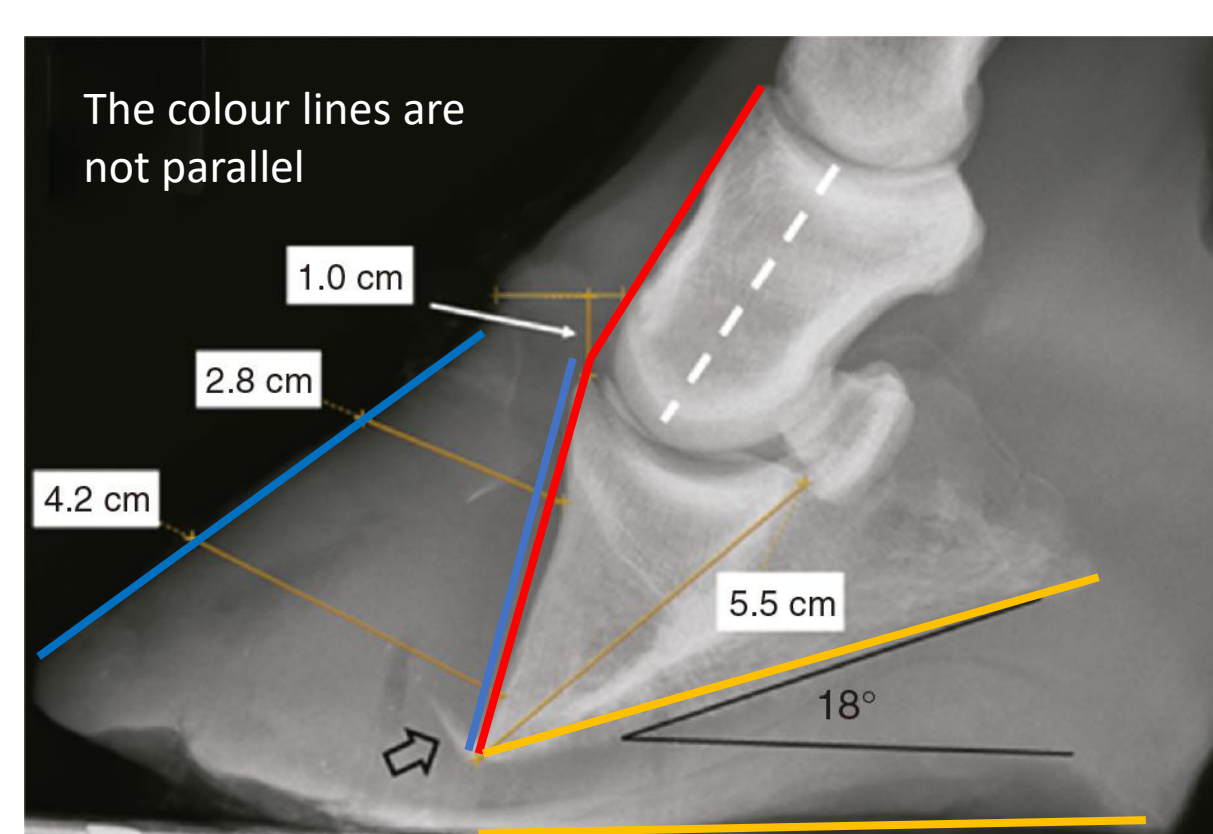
Radiograph of the third phalanx rotation, adaptation (Parks and Belknap (2016)).
